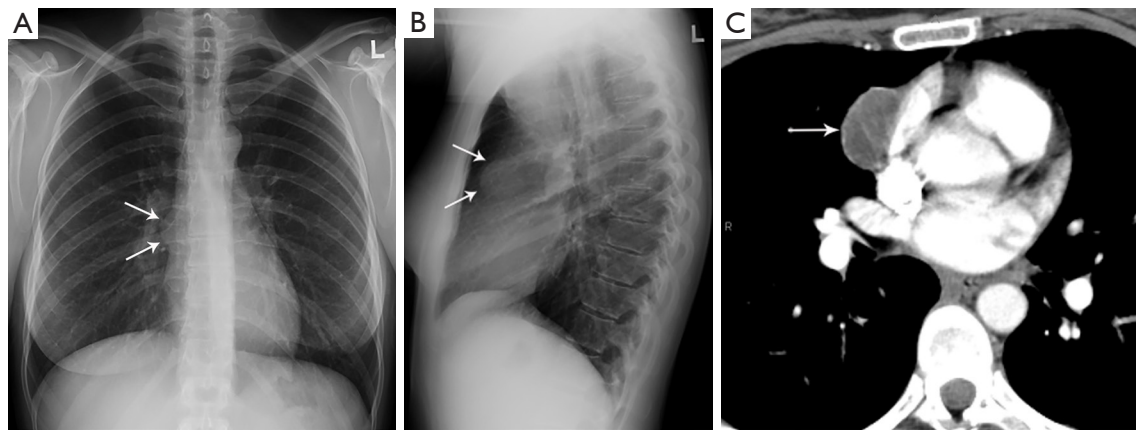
Pericardial cyst. (A,B) Frontal and lateral chest radiograph shows subtle contour abnormality (arrows) with loss of the silhouette of part of the right mediastinal border termed the “silhouette sign”. (C) CT shows low attenuation consistent with pericardial cyst (arrow). CT, computed tomography.
